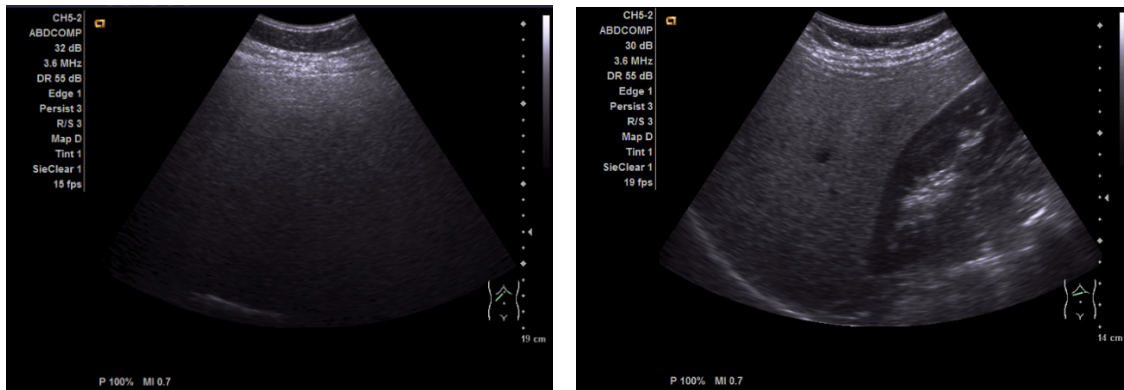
Ultrasonographic Aspects of Hepatic Steatosis
